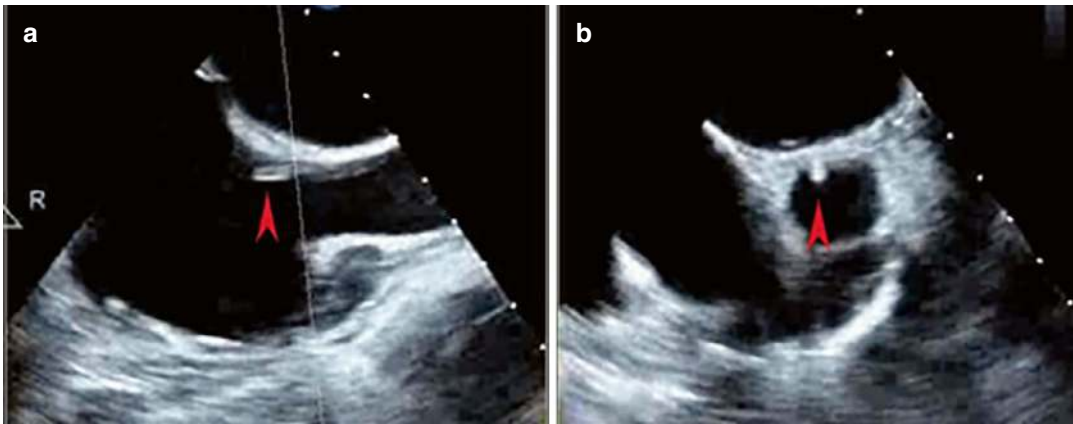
Two-panel ultrasound images labeled “a” and “b” showing heart structures. Both panels feature a red arrow indicating specific areas of interest. The images display
